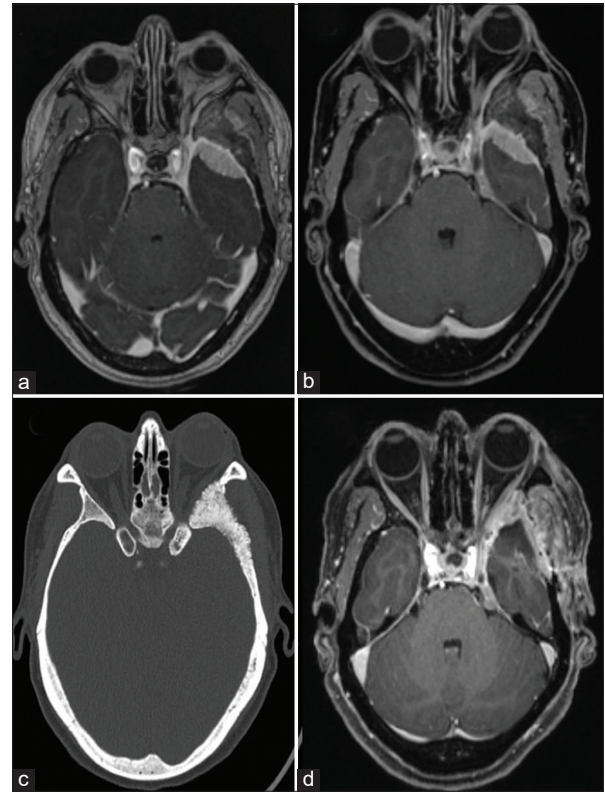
Case 1. (a and b) Preoperative T1-weighted postgadolinium administration MR images demonstrating left SOM with extension into the superior orbital fissure, left cavernous sinus, left petrous apex, and left cerebellopontine angle (CPA). (c) Preoperative CT head bone window demonstrating hyperostosis. (d) Postoperative T1-weighted postgadolinium administration MR images demonstrating postoperative changes as well as residual lesion at the left cavernous sinus and CPA.
